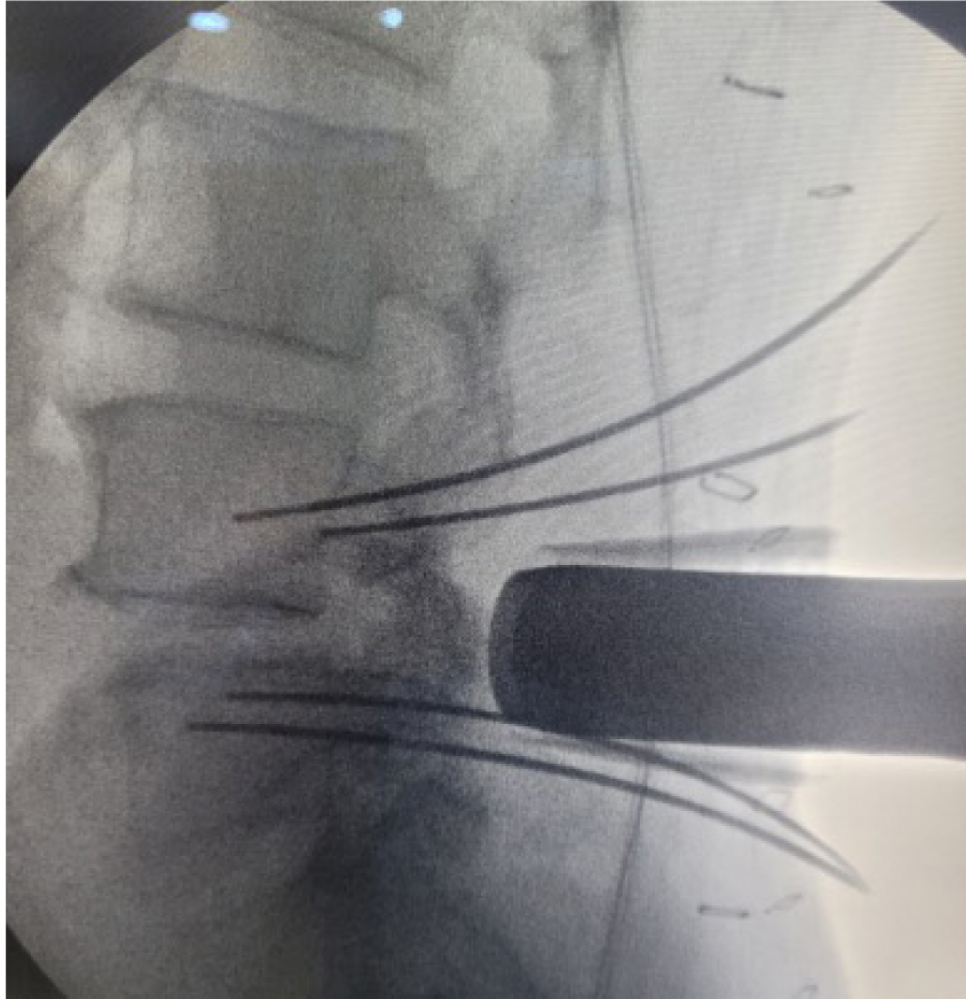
Lateral X-ray showing one of the K wire was displaced outward (arrow) during docking of the tubular retractor to perform a facetectomy for MISS-TLIF. This was identified and the wire was replaced and carefully secured.
